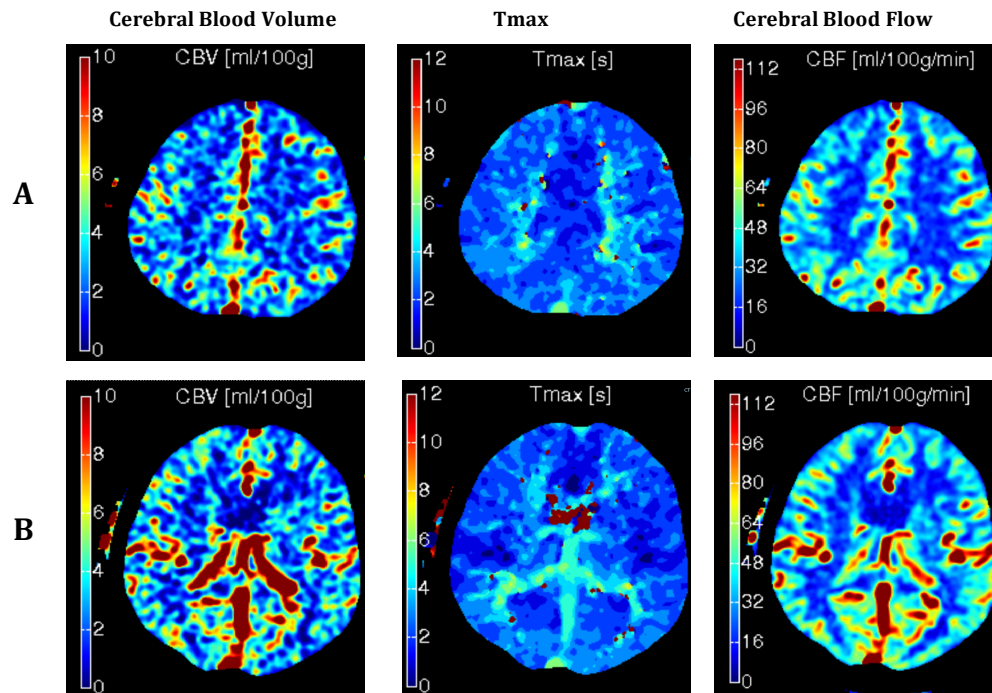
Example of ASPECTS 10 on CT Perfusion
